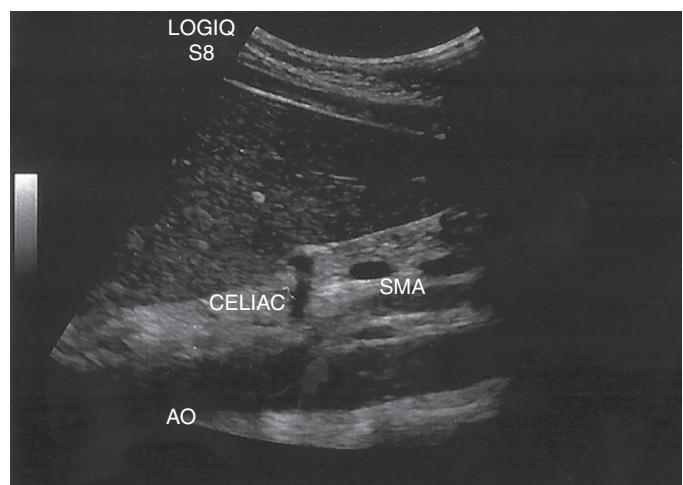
Doppler ultrasound image representation of normal findings and positioning during dynamic studies for median arcuate ligament syndrome.
